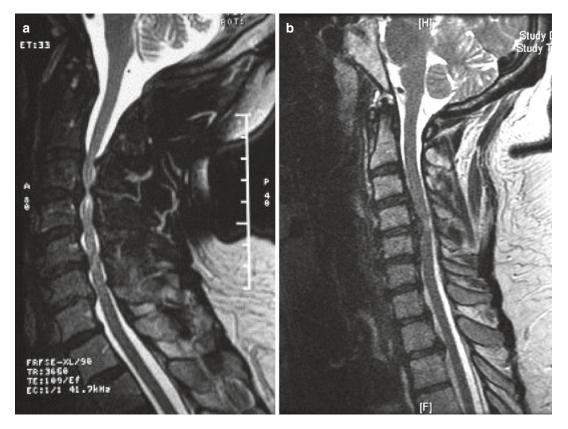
T2-weighted sagittal MRI images contrasting patients who would be good candidates for posterior (a) versus anterior (b) surgical approaches to cervical spondylosis
